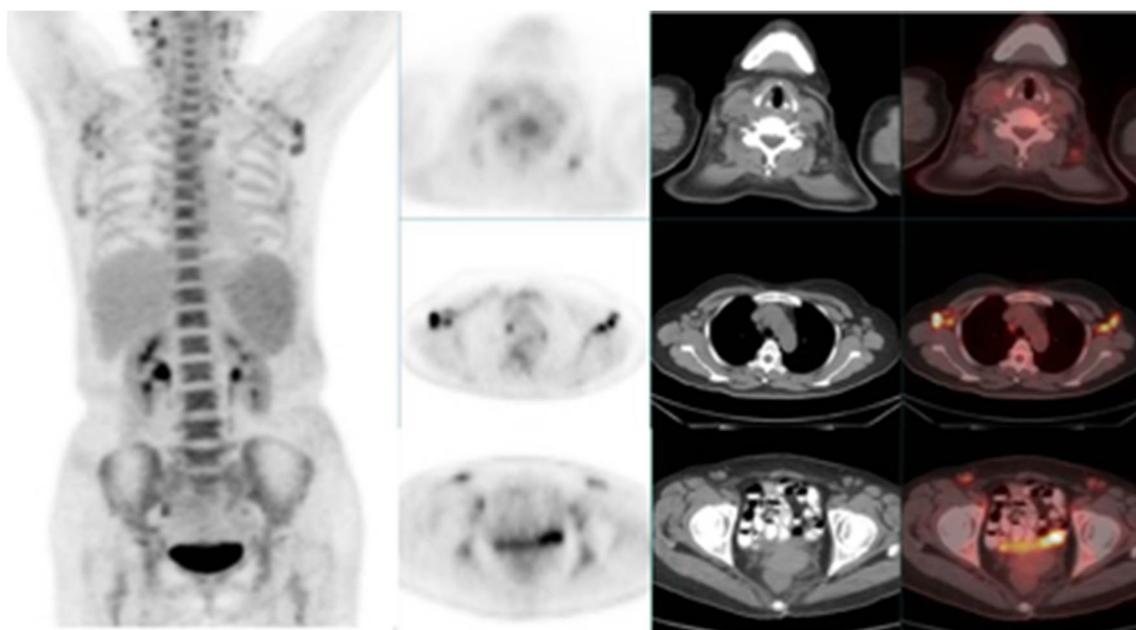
FDG PET/CT images of a 28-year-old woman with FEO. FDG PET/CT show diffuse high uptake in spleen and bone marrow, and multiple reactive hyperplasia lymph nodes symmetrically distributed in bilateral neck, axillary and groin. The final clinical diagnosis is adult-onset Still's disease
